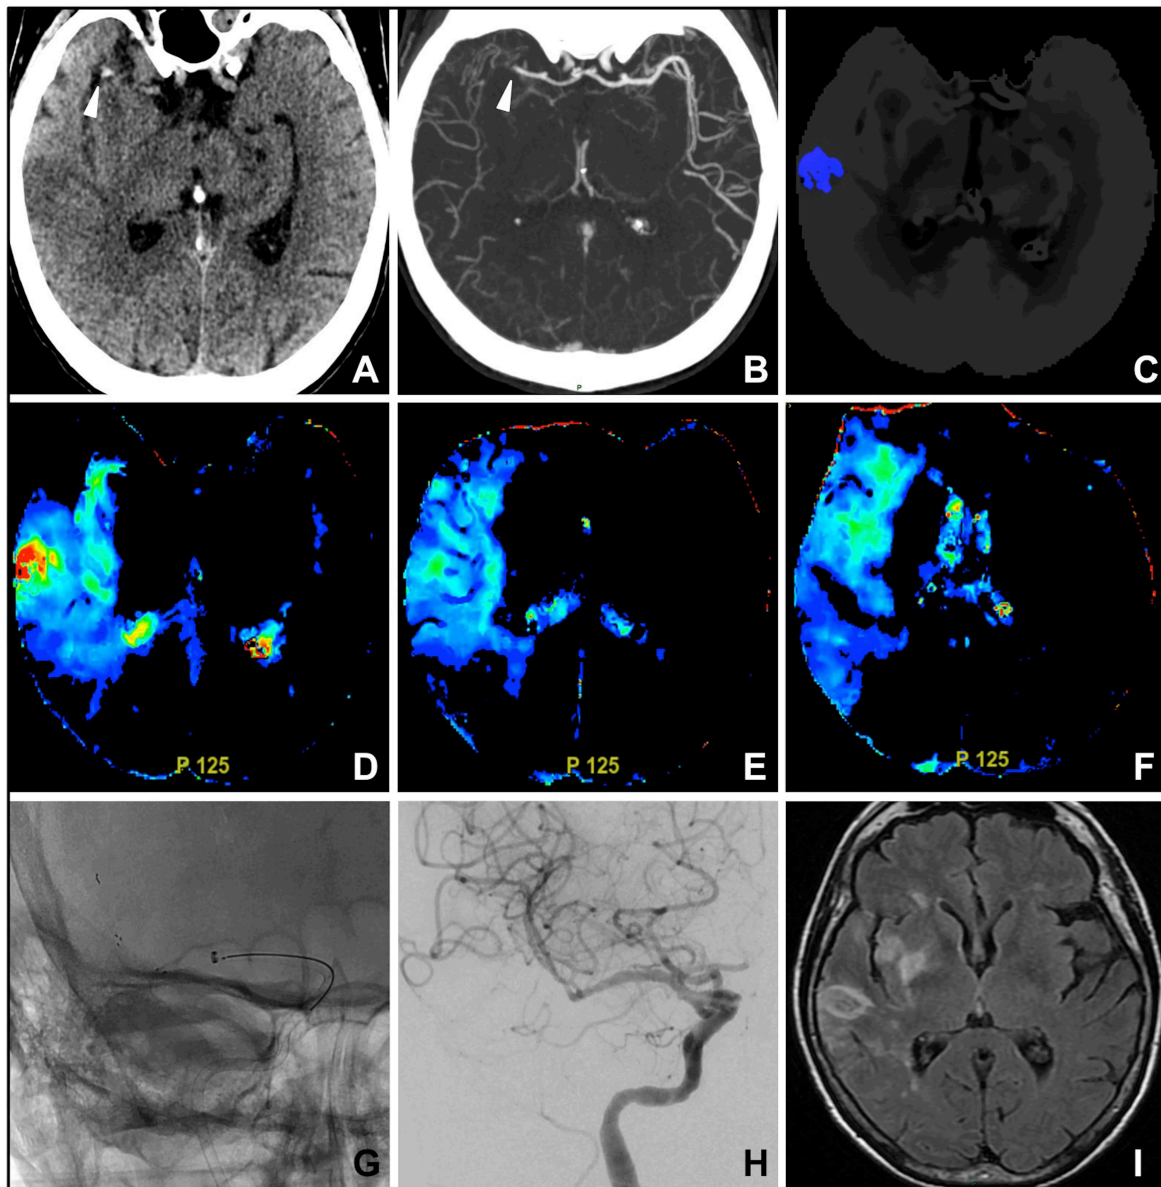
Representative cases. Axial non-contrast CT image (A) showing a hyperdense vessel sign (arrowhead) and a small core of infarction in the right temporal lobe. The CTA (B) shows the M1 segment (arrowhead) occlusion and prominent collateral circulation. The $T_{max16s-25s}$ map confirms the small temporal lobe core of infarction (C), while the $T_{max9.5s-25s}$ maps (D–F) show the extended area of ischemic penumbra in the fronto-insular and temporal lobes. Mechanical thrombectomy using a combination of stent-retriever and a 6F distal aspiration catheter (G) leads to complete recanalization of the vessel (H). The follow-up RMN study shows the pre-treatment temporal ischemic core and two small not-symptomatic new ischemic lesions in the right insula and caudate nucleus (I).
